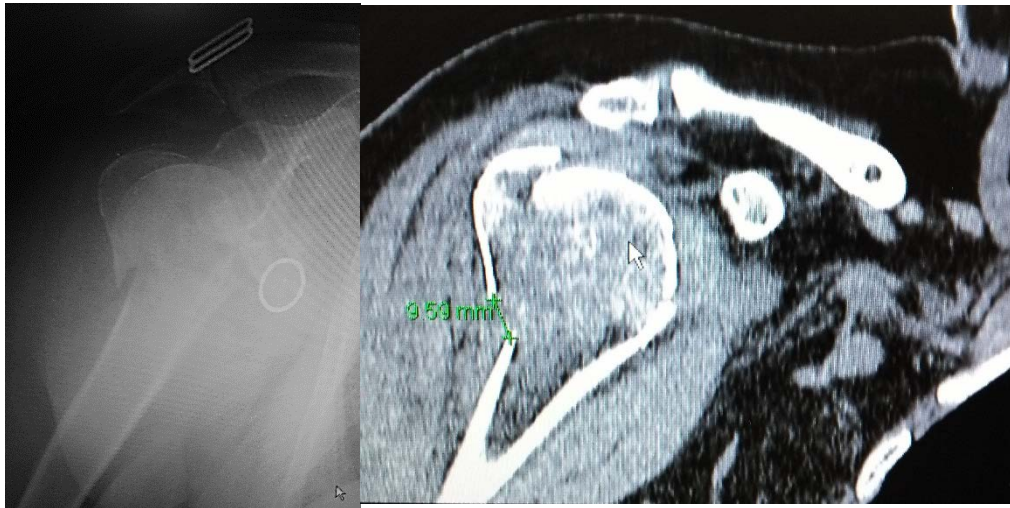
Proximal humeral fracture: Plain X-ray (left) and coronal CT (right) showing three part proximal humeral fracture with postero-superior displacement of the greater tuberosity and valgus impacted head.
